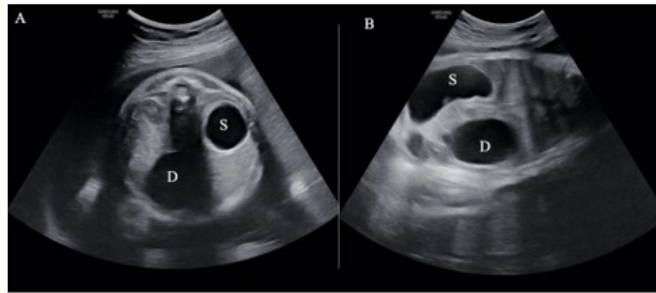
Prenatal ultrasonography on axial (A) and coronal (B) sections of the fetal abdomen: Two distended cystic bubbles, producing the fetal double-bubble sign indicating the stomach (S) and the duodenum (D).
